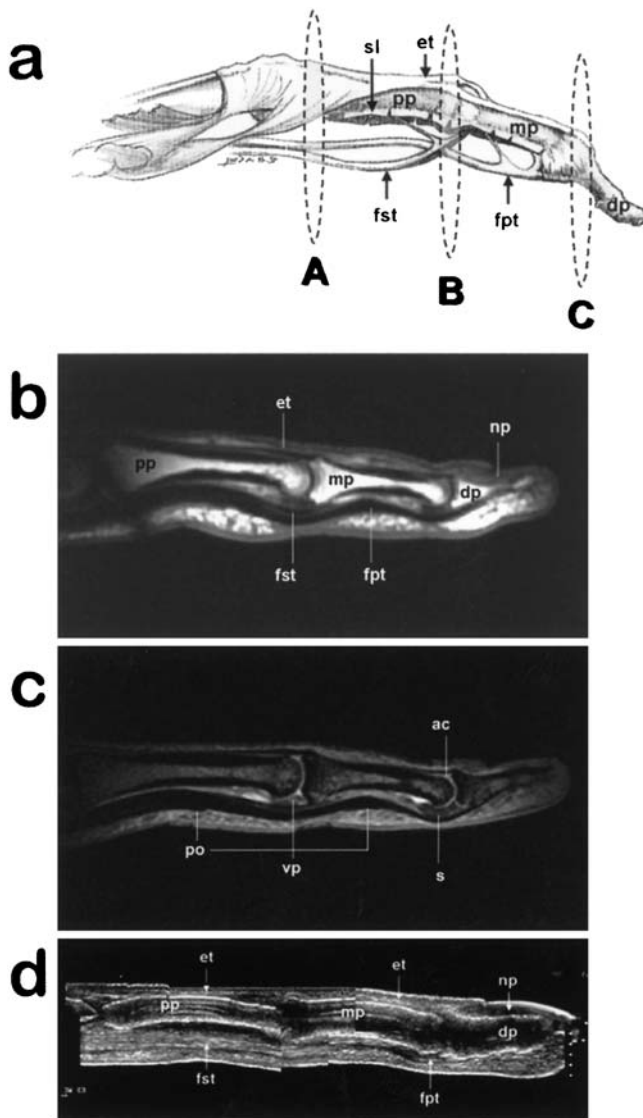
Sagittal anatomic images. a Sagittal image of finger. b Sagittal T1-weighted spin-echo (SE) MR image (TR/TE/slice thickness: 400 ms/14 ms/2 mm). c Sagittal gradient-echo (GE) MR image (TR/TE/slice thickness: 400 ms/14 ms/2 mm, flip angle 20°). d Sagittal ultrasound image. *ac* articular cartilage; *dp* distal phalanx; *et* extensor expansion tendon; *fst* flexor digitorum superficialis tendon; *fpt* flexor digitorum profundus tendon; *mp* middle phalanx; *np* nail plate; *po* pulley of the flexor tendon; *pp* proximal phalanx; *s* sesamoid bone; *sl* sheath laid; *vp* volar plate
